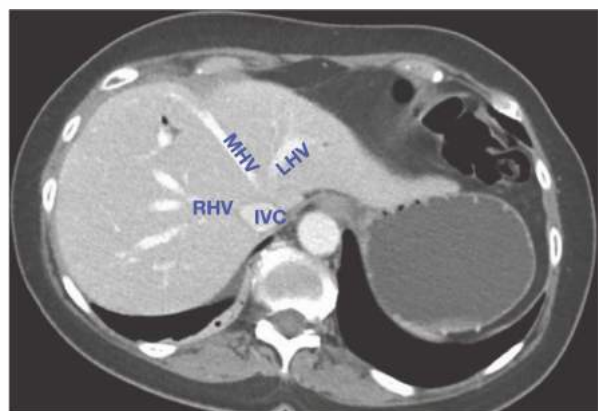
• Axial CT image showing the MHV, which separates the right and left hemilivers. The IVC, left hepatic vein (LHV), and the branching of the right hepatic vein (RHV) are also shown.
